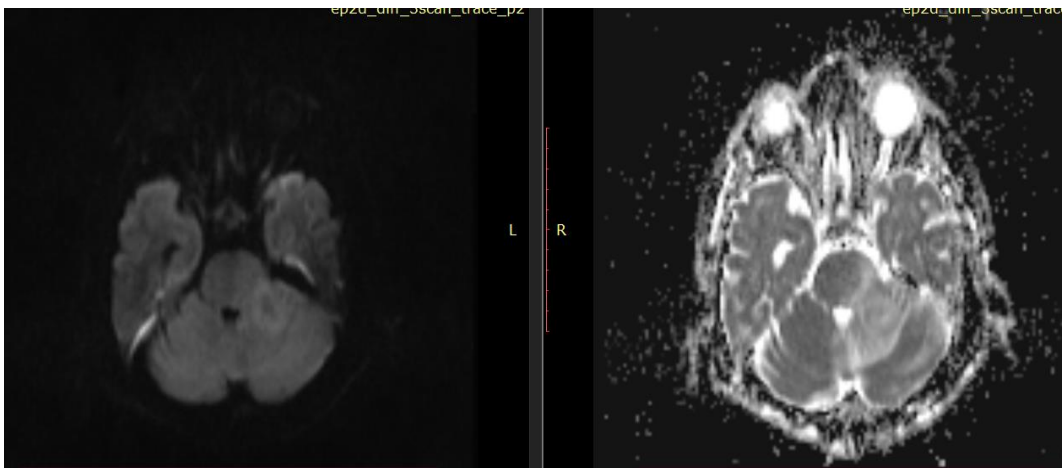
MRI scans of the brain
